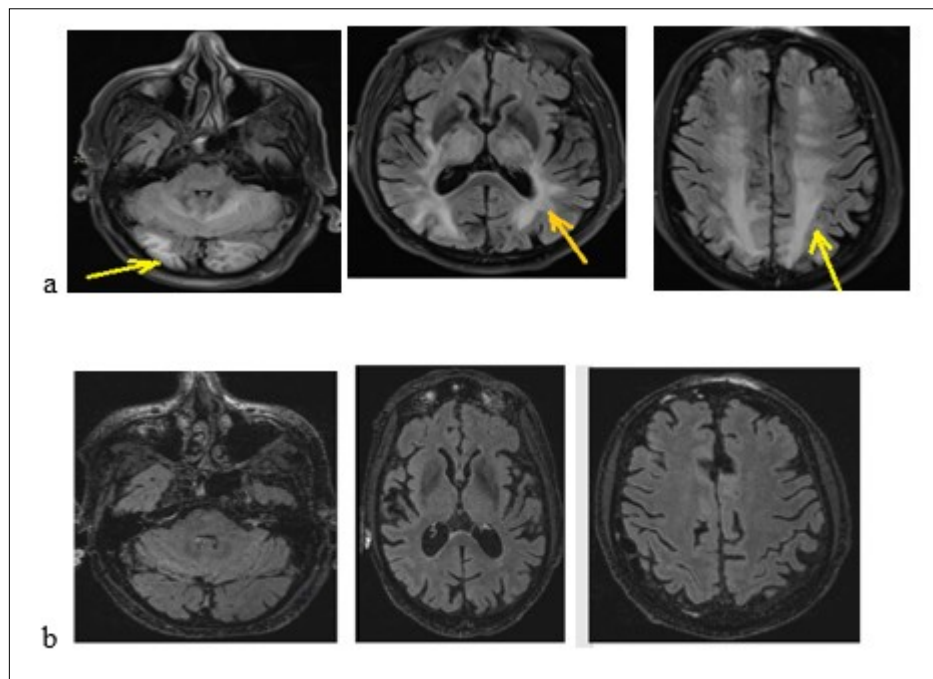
Brain MRI with flair sequences showing hyper signals of white matter and cerebellum corresponding to edema (a) and the decrease of lesions after treatment (b).
